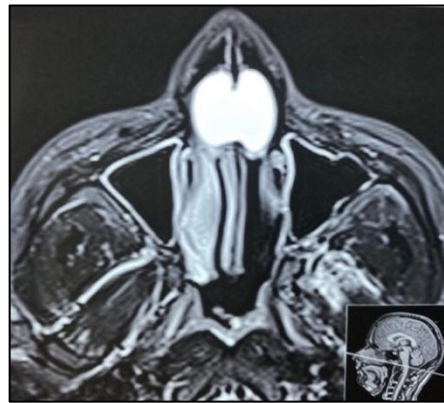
MRI showing Iso- to intermediate in T1 and high signal intensity in T2 in the cartilaginous septum without intracranial extension
